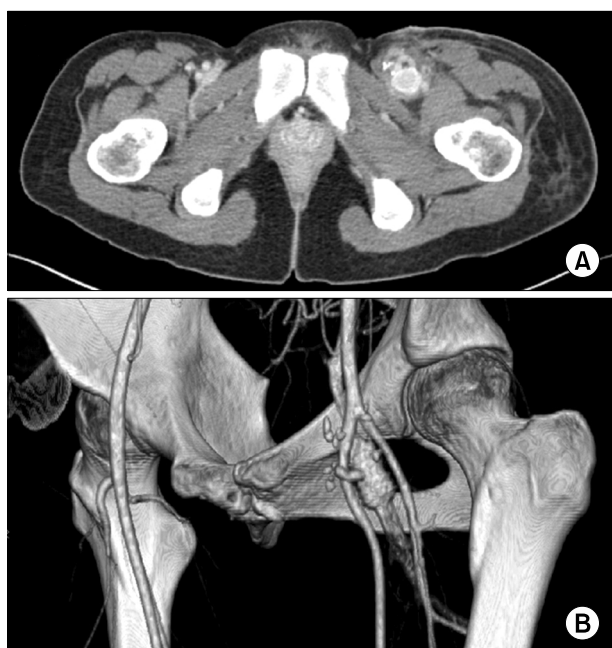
(A, B) Computed tomography images obtained at 7 days after surgery confirmed patency of the left femoral vein and arteriovenous fistula.
